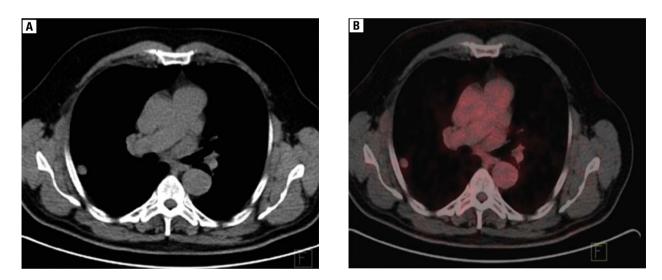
Benign mass localised in the right lung shows little 18F-FDG uptake on PET-CT image Rycina 2. Zmiana ogniskowa w płucu prawym o charakterze łagodnym i słabym gromadzeniu znacznika w PET-CT
